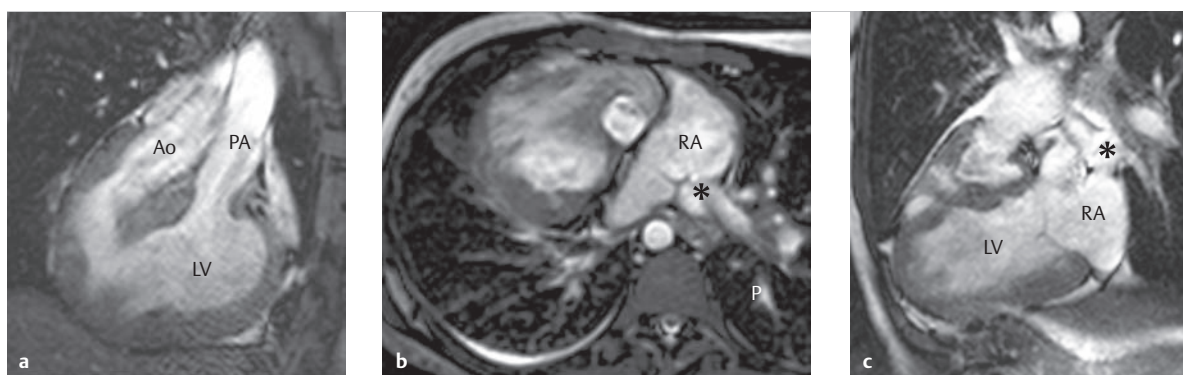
Complete situs inversus and cardiac TAPVR with direct connection of all pulmonary veins to the right atrium. Various SSFP cine MRI of a male child.
